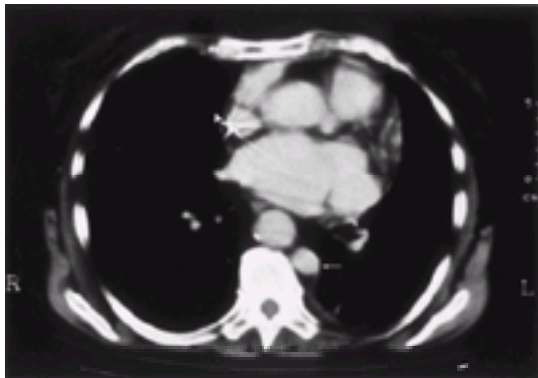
Contrast enhanced CT scan of the patient with hemiazygos continuation of the inferior vena cava shows a left intrathoracic inferior vena cava (arrow). The pacemaker wire is seen in the right superior vena cava (arrowhead).
